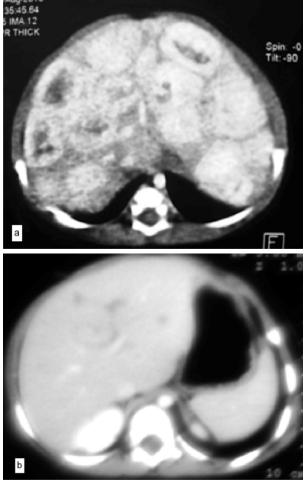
(a) Contrast-enhanced computed tomograph of abdomen in venous phase showing diffuse involvement of liver by hemagiomas, (b) Post-propanolol therapy showing complete resolution of hemagiomas.
